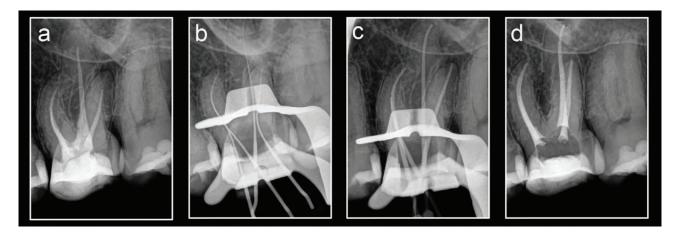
(a) Preoperative peri-apical radiograph of maxillary left first molar with previous root canal treatment. Note that all three obturated root canal systems were treated short of full working length; (b) Length determination peri-apical radiograph; (C) Conefit peri-apical radiograph; (d) Postoperative peri-apical radiograph after obturation
